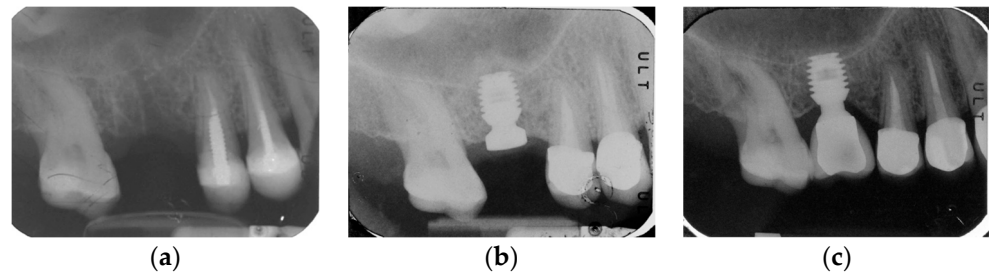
Radiograph obtained before implant placement (a), at time of implant placement (b), and at time of loading (c) of a short (4.5 × 6 mm) locking-taper implant in 1.6 sites.
